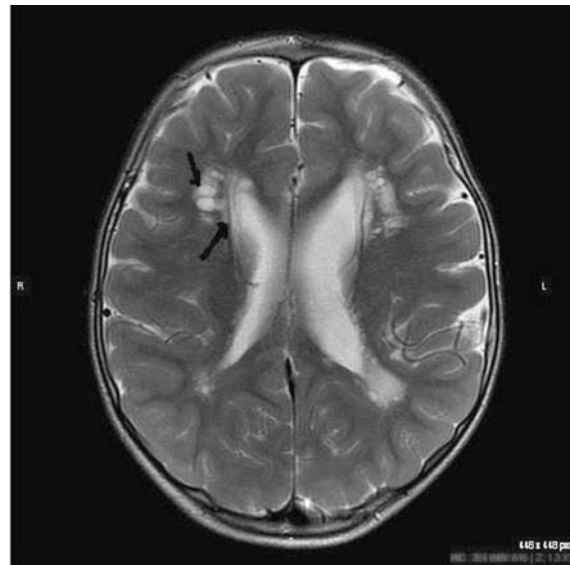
Lacunar lesions and bilateral periventricular leukomalacia on T2-weighted MRI.
